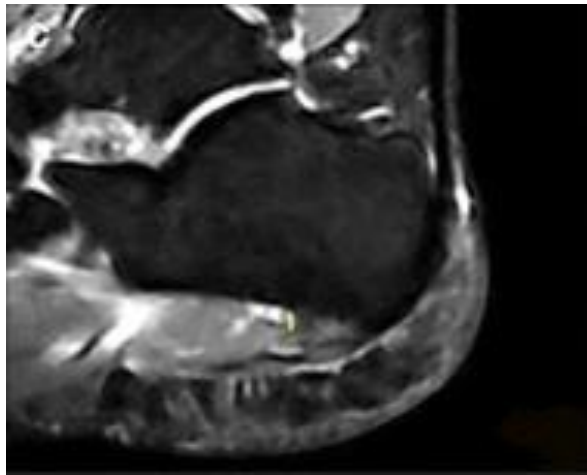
MRI fluid-sensitive image (c). Oedema of the bone marrow in the heel (calcaneal) spur (Draghi et al., 2017)
